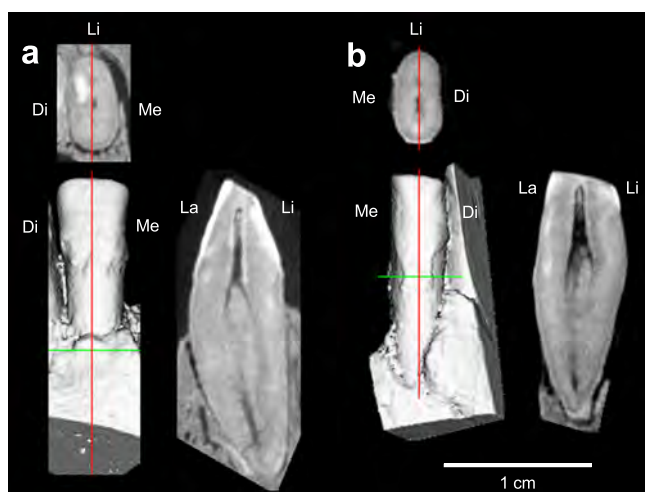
CT sections of the LB1 mandibular incisor roots. Sagittal (top) and horizontal (right) sections are shown for right I_2 (a) and left I_1 (b). The lower left image for each tooth is a surface rendered image of the labial side, which indicates the levels of the sections (vertical and transverse lines). Me = mesial, Di = distal, La = labial, Li = lingual. Note the convex labial and lingual root outlines similar to LB6/14, the isolated I_1 shown in Figure 4.
